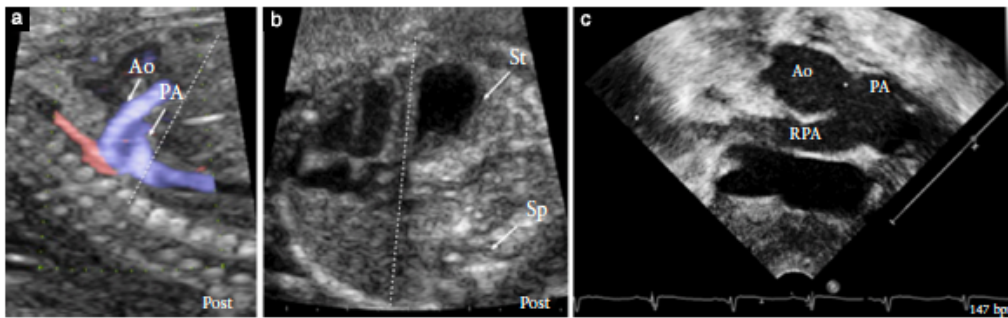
Fetal echocardiography at 20 + 4 weeks' gestation in Case 3, showing aortopulmonary window (APW) in: (a) parasagittal plane, showing abnormal position of great vessels close to diaphragm (dotted line) and (b) oblique view, showing four-chamber view and stomach (St) in same plane. (c) Postnatal echocardiography in same case showing APW (*) in subcostal position. Ao, aorta; PA, pulmonary artery; Post, posterior; RPA, right pulmonary artery; Sp, spine.
